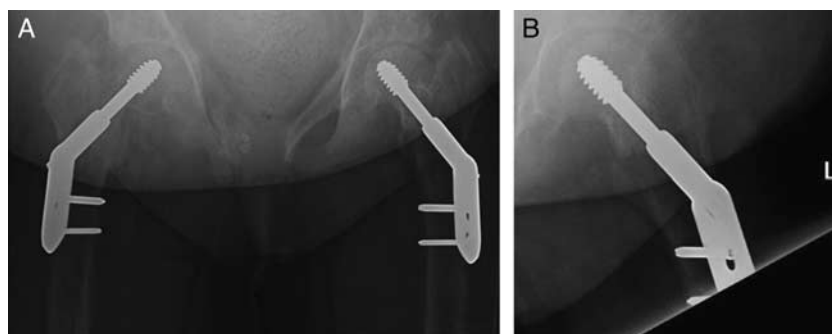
Anteroposterior pelvis (A) and lateral left hip (B) plain radiographs taken 4 weeks postoperatively showing satisfactory positioning of both dynamic hip screw devices.
